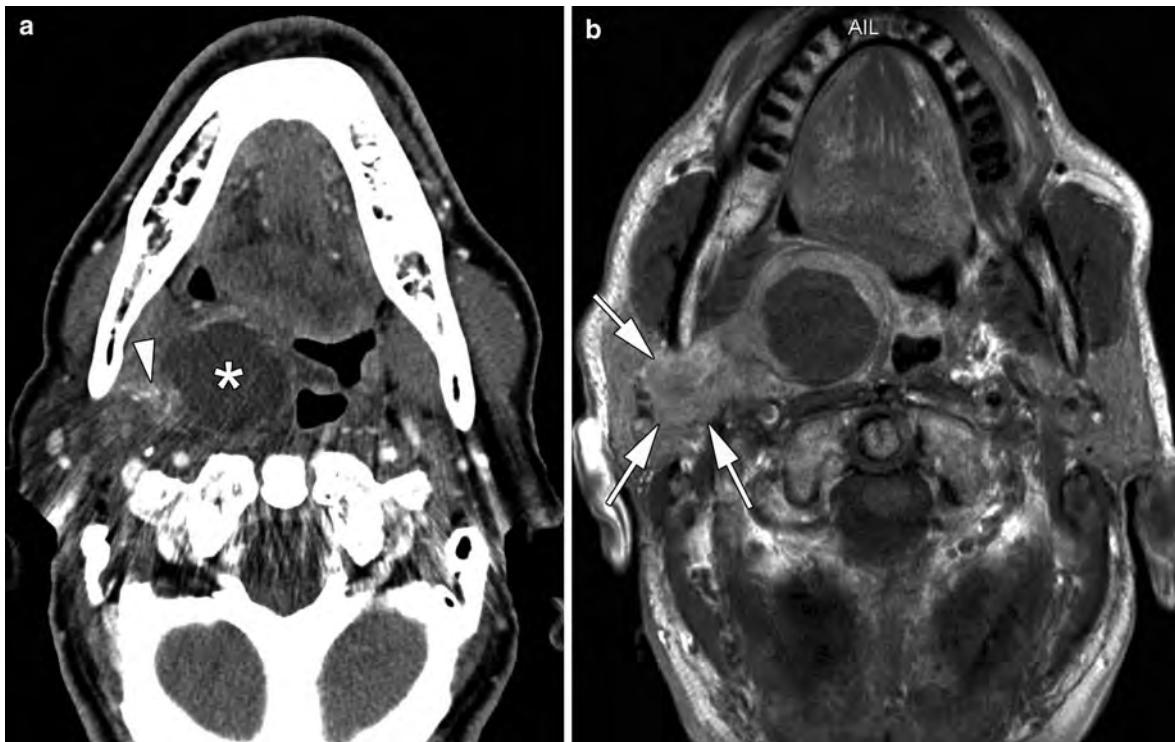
Elderly patient presenting with right-sided throat pain. Clinical examination shows a swollen tonsil, no fever. Axial contrast-enhanced CT image (a) shows a large fluid-filled mass lesion (*asterisk*) in the prestyloid compartment of the PPS; this may be confused with a peritonsillar abscess. However, a solid component (*arrowhead*) with some small calcifications is seen at its lateral side, suggesting a tumor
